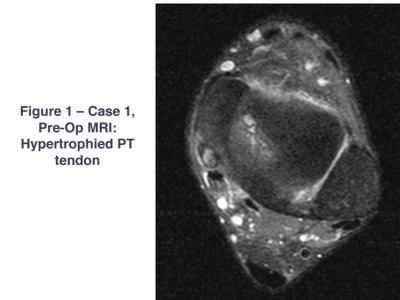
Case 1, Pre-Op MRI: Hypertrophied PT tendon
